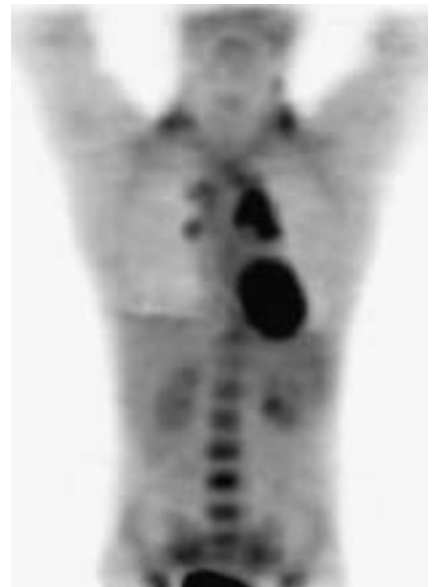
A PET image of a 14-year-old girl with stage IIIA nodular sclerosing Hodgkin's disease (HD) shows disease in the neck, mediastinum, and abdomen. There is homogeneous, prominent marrow activity. Bone marrow biopsy was negative for disease. The bone marrow is a metabolically active organ, and diffusely increased FDG uptake reflects increased metabolism, and hence increased glucose consumption, in response to hematologic stress. This pattern should not be interpreted as indicative of diffuse marrow disease.
